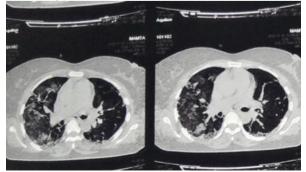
CT showing features of ILD
